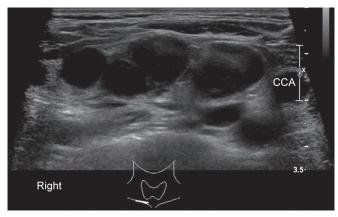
Ultrasound of patient's neck region revealing multiple enlarged lymph nodes seen predominantly along the right side of the neck
